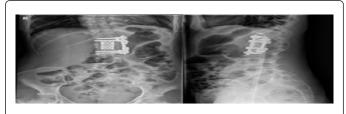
Plain AP A). and lateral B). radiographs, Corpectomy of L1 with anterior interbody fusion using Mesh Cages and rib bone graft was performed.
